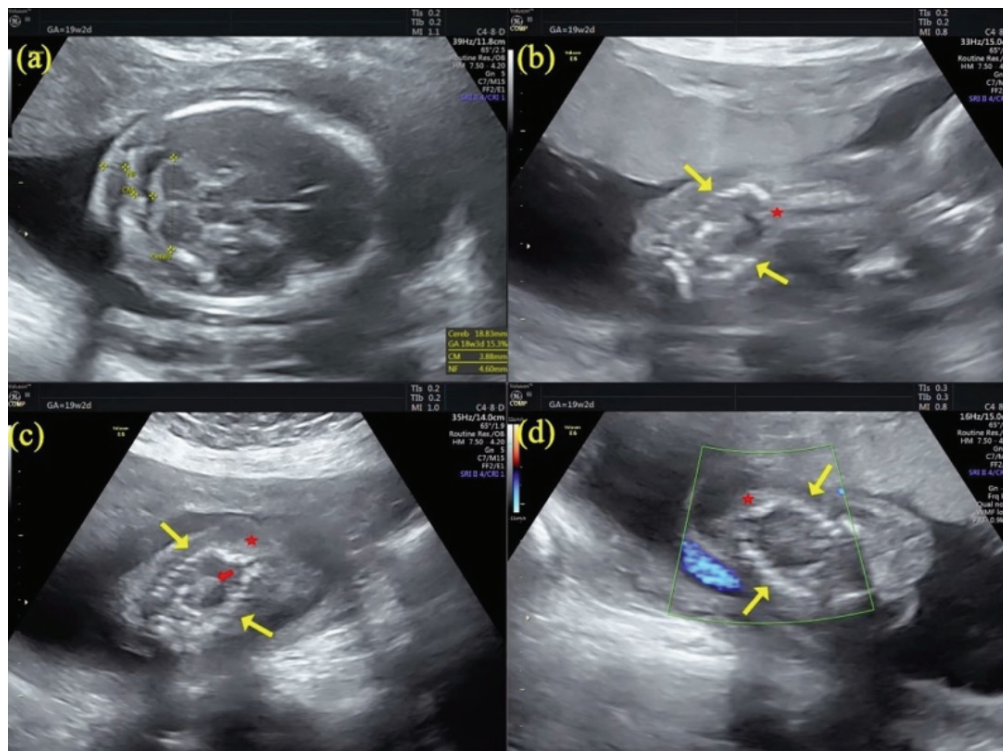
Ultrasonographic images of fetal spine duplication with lipomyelomeningocele. In the axial transcerebellar section, the cerebellum is in normal shape and the posterior fossa is open (a). Ultrasonographic images of the duplication and separation of the thoracolumbar spine distal to the T8 vertebra (Red star) in the evaluation of the spine in the dorsal coronal section (Yellow arrows mark right and left vertebrae) (b, c). The hyperechoic appearance (Red arrow) between the duplicated vertebrae was diagnosed as the lipomatous part of the lipomyelomeningocele at fetal autopsy (c). In color Doppler examination, no flow is observed in the mass between the vertebrae (d)
